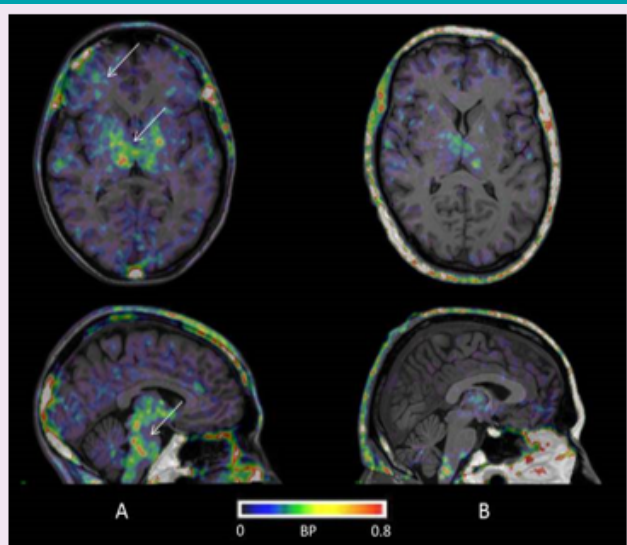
Increased $[^{11}\text{C}](\text{R})\text{-PK11195}$ binding potential (BP) in a presymptomatic HD gene carrier (A) in comparison with a healthy control (B). BP maps are co-registered to the individual T1 MRI. The colour bar denotes BP values 0- 0.8
